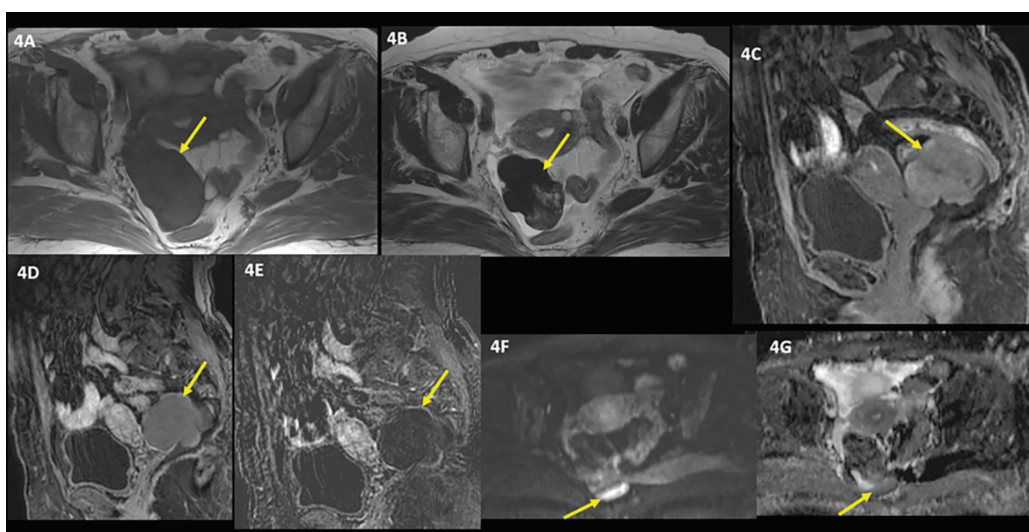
A 77-year-old woman with postmenopausal complaints. In the right ovary, a solid lesion measuring 70x47x60 mm, heterogeneous, iso- to mildly hypointense in T1-weighted (T1W)s compared to the striated muscle (Figure 4A arrow) and fat-saturated T1W (Figure 4C arrow), markedly hypointense in T2-weighted (Figure 4B arrow), with millimetric cystic areas was observed. In the post-contrast series, mild heterogeneous contrast enhancement was detected in the late phase (Figure 4D arrow and subtraction Figure E arrow), and a lobulated-contour solid lesion containing partially diffusion-restricted areas (Figures 4F and G arrows) was observed on diffusion-weighted imagings (proven by biopsy fibrothecoma)
